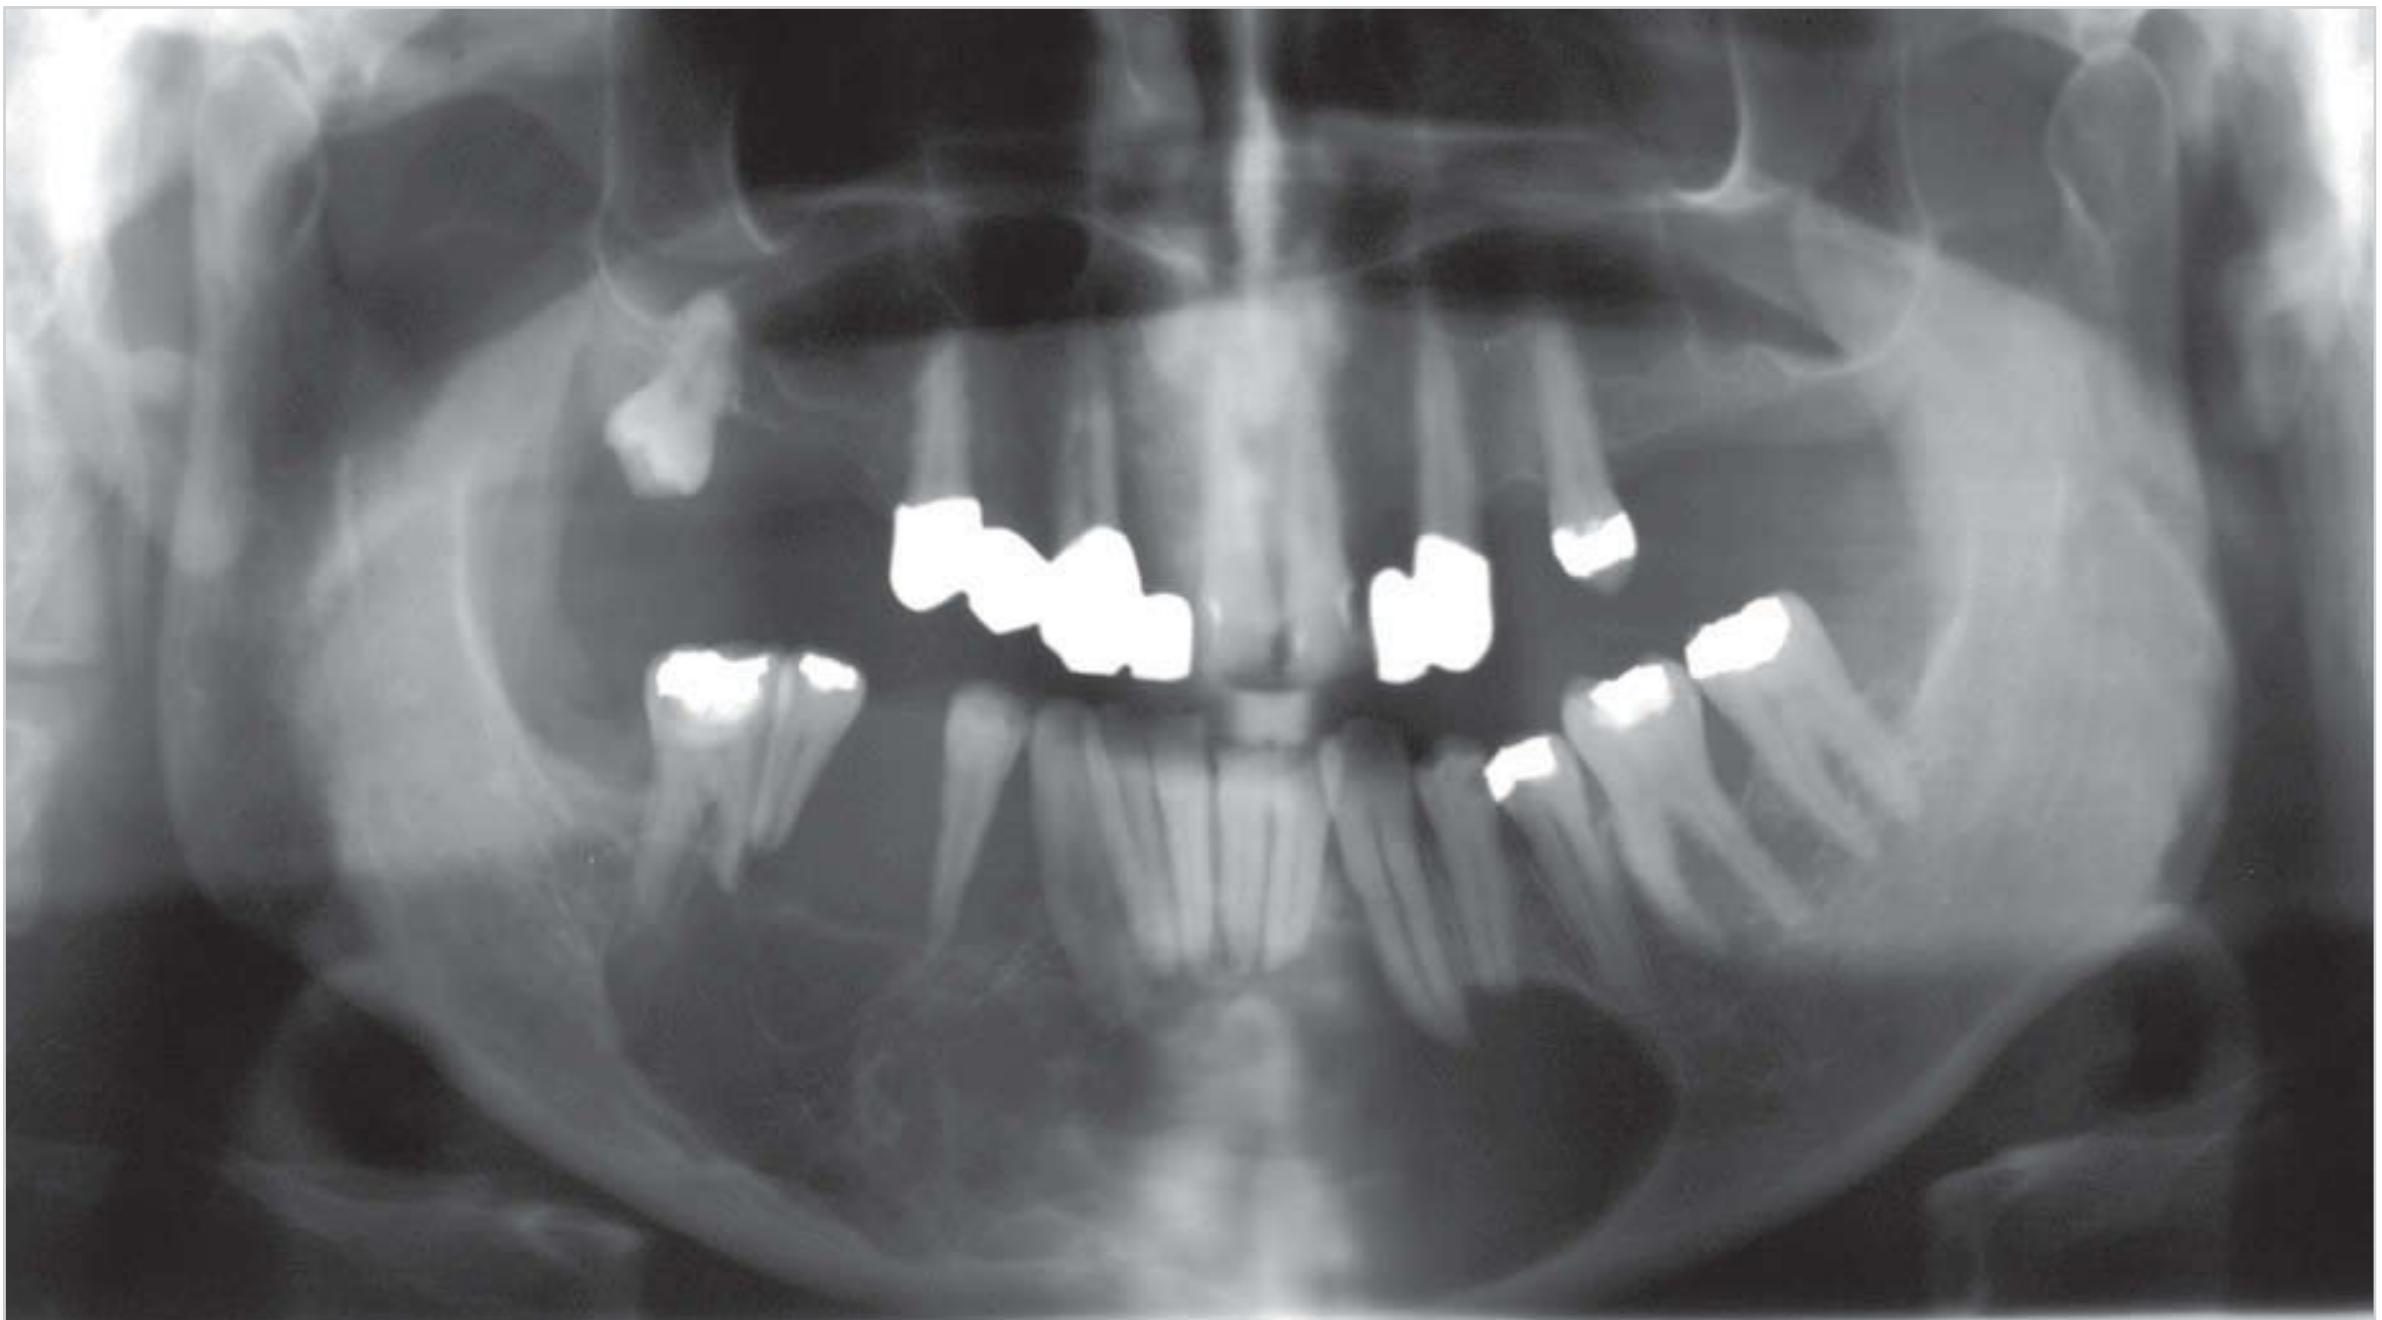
Odontogenic myxoma (myxofibroma): The radiograph reveals a large radiolucency that extends from tooth 35 to tooth 46 and contains trabeculae. The teeth appear to be slightly tilted. Resorption of the roots of teeth 34 and 32 cannot be excluded.
